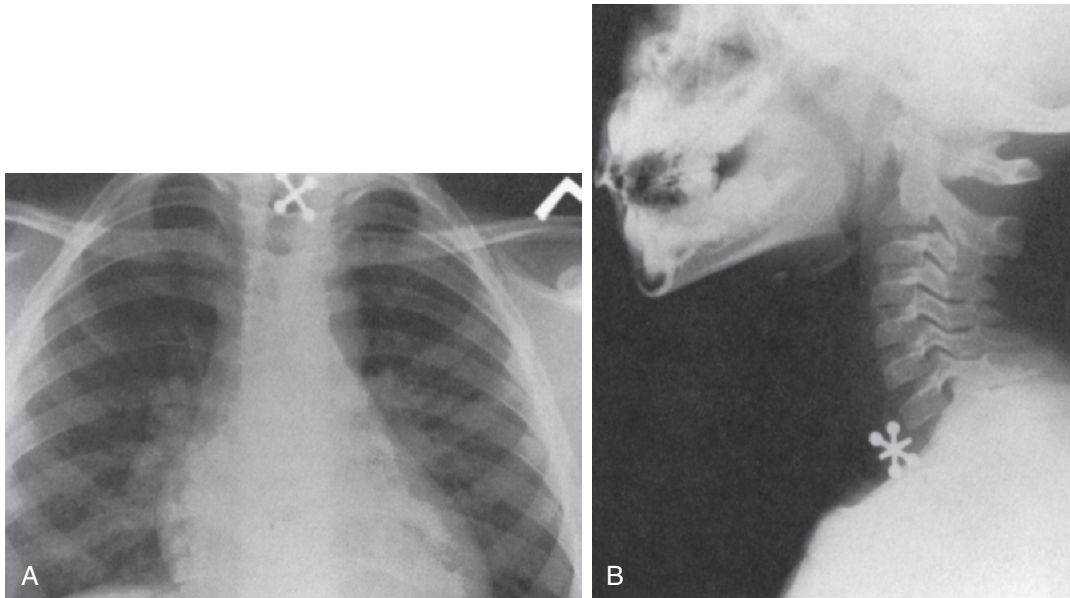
Foreign body obstruction. Posteroanterior (A) and lateral (B) chest radiographs reveal an esophageal foreign body that caused respiratory distress from posterior pressure on the trachea.
